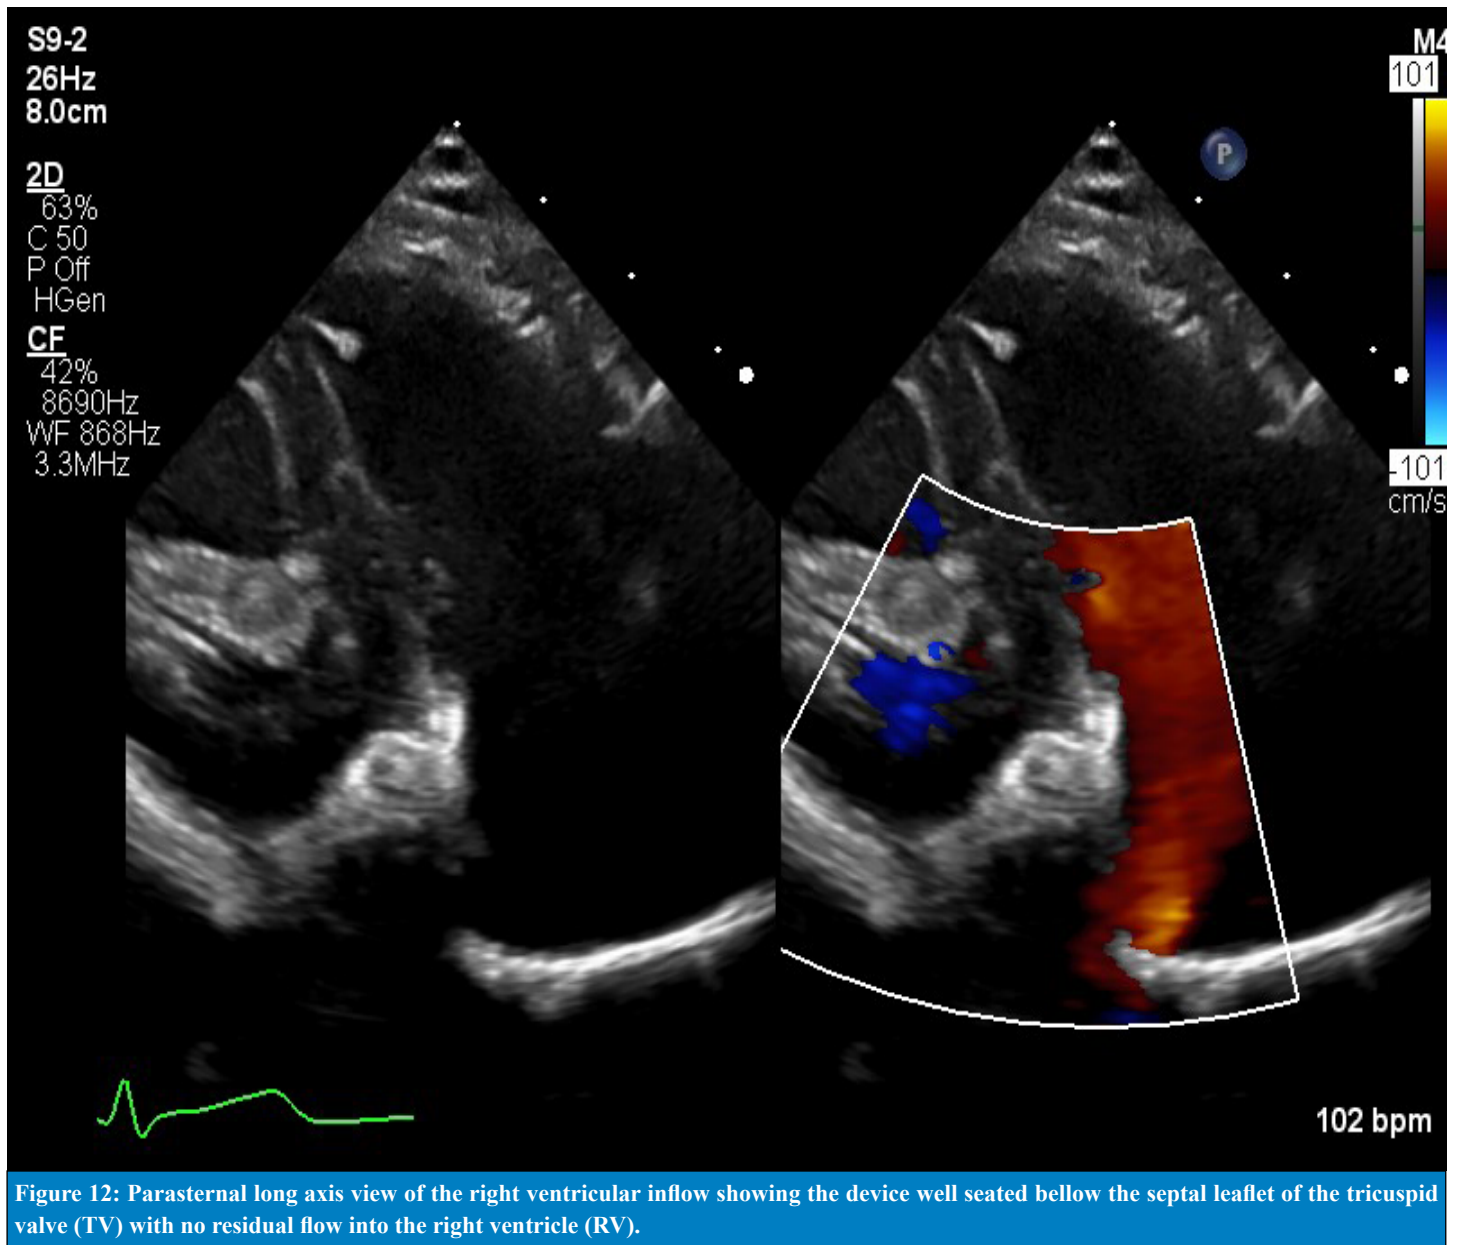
Parasternal long axis view of the right ventricular inflow showing the device well seated below the septal leaflet of the tricuspid valve (TV) with no residual flow into the right ventricle (RV).
